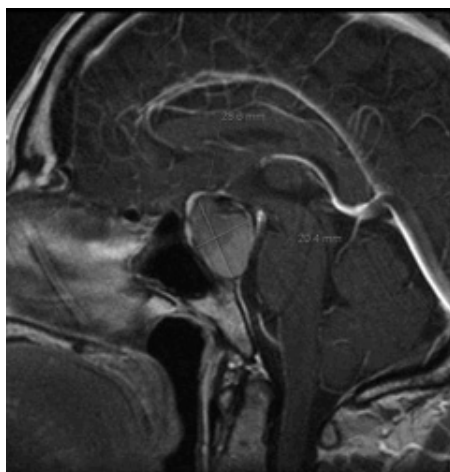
Magnetic resonance imaging of the brain (midsagittal view).
